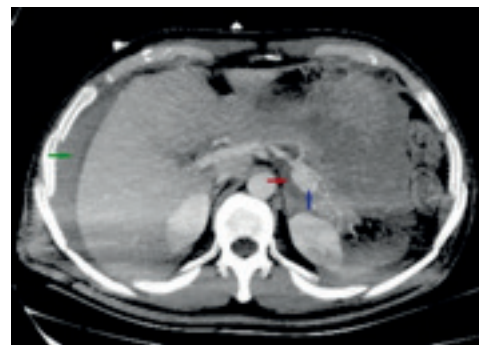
In another horizontal CT section, the blue arrow indicates the splenic artery aneurysm, the red arrow highlights the hematoma surrounding the aneurysm, and the green arrow shows the perihepatic hemorrhagic fluid
